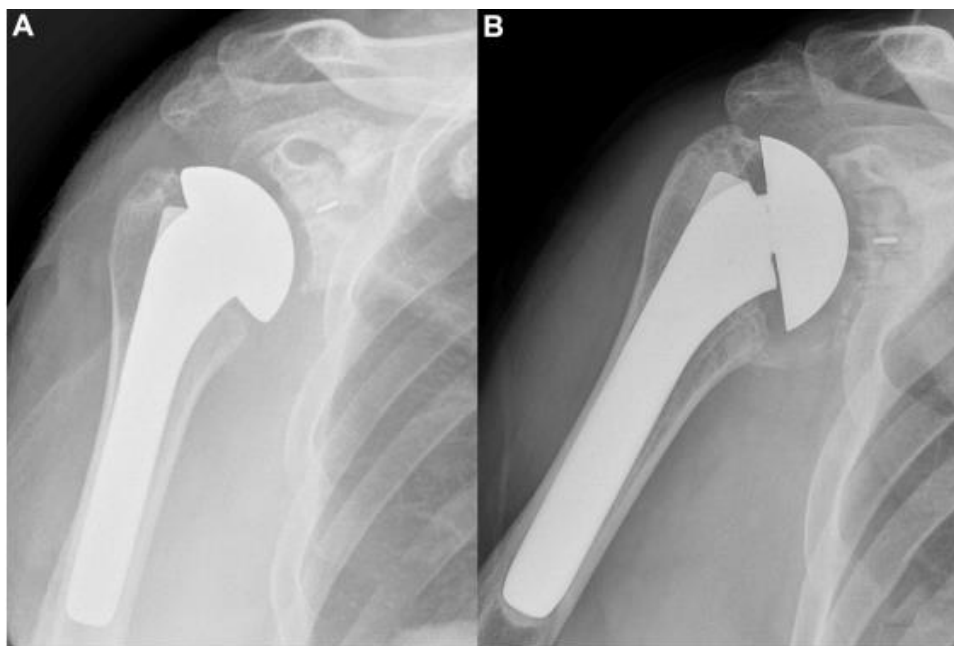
(A) Early postoperative x-ray of the shoulder. (B) 5-year postoperative x-ray of the GH joint with lucency around the all-polyethylene implant [36].
